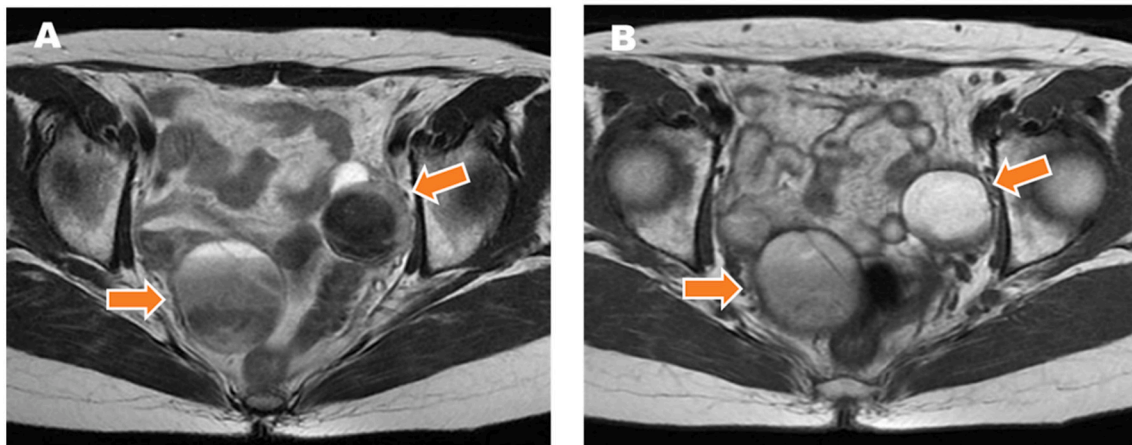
MRI findings of (A) axial T2-weighted image and (B) axial T1-weighted image revealing a right pelvic multilocular cyst (7 cm in diameter) (arrows) and a left unilocular cyst with high-signal intensity on the T1-weighted image (arrows).
